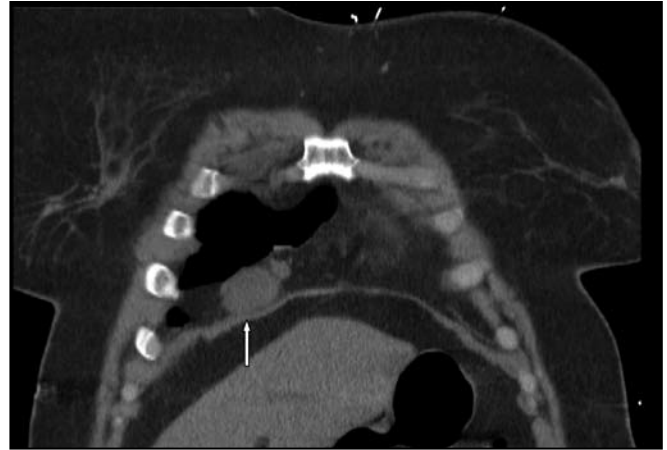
Coronal reconstruction of a nonenhanced computed tomogram of the chest reveals a lobular pleural-based mass (arrow).
